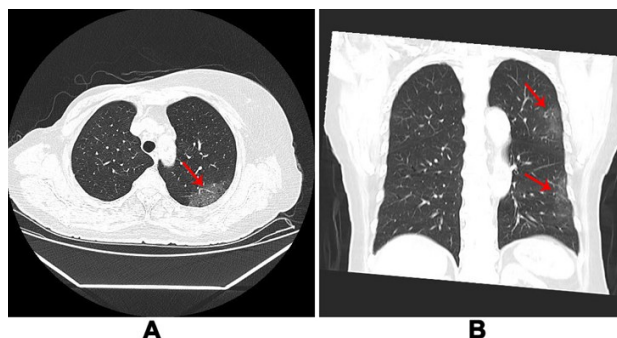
CT scan of a 70-year-old asymptomatic female presenting with increased CRP level and normal white blood cell, lymphocyte and neutrophil counts. A-B: Scans showing multiple ground-glass density foci in both lungs; blurred borders; and thickened, rough, and deformed internal blood vessel branches. CRP: C-reactive protein.
